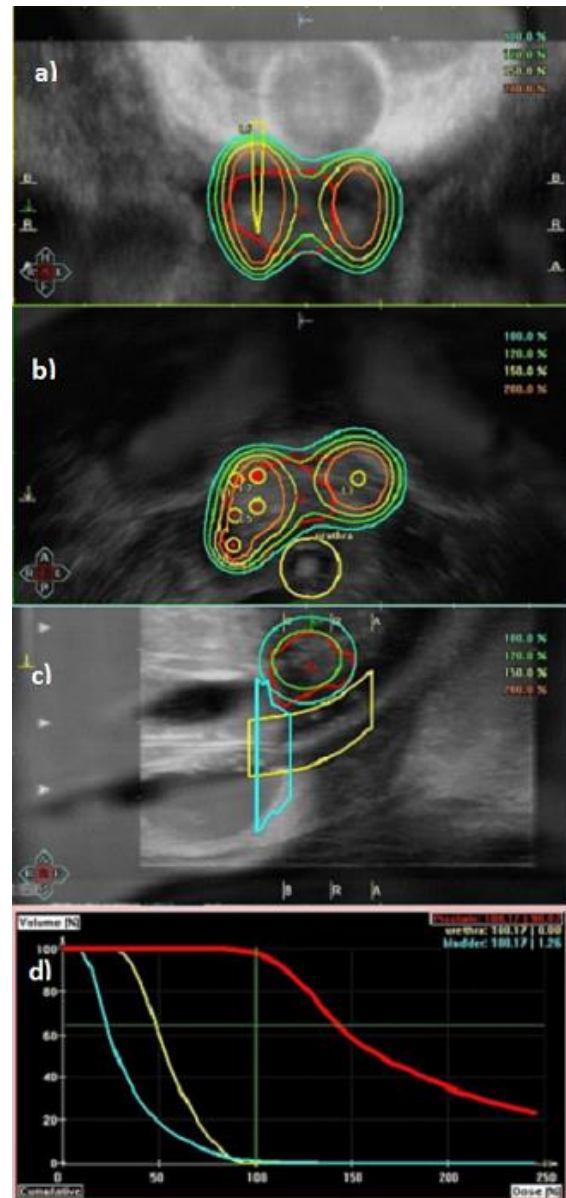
a) Coronal plane, b) transverse plane and c) sagittal plane showing delineations of the PTV, urethra and bladder, the reconstructed catheters and the isodose curves on the MRI-US registered images. d) Cumulative DVH.
